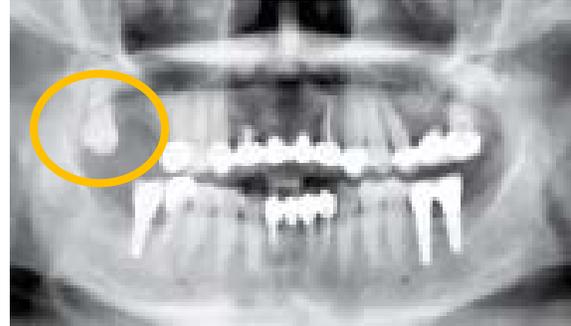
Pre-operative radiograph prior to sinus lift.
